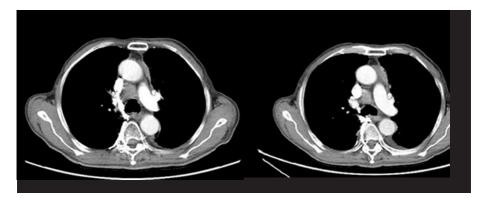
CT performed on 8/4/2017 and 6/15/2018
